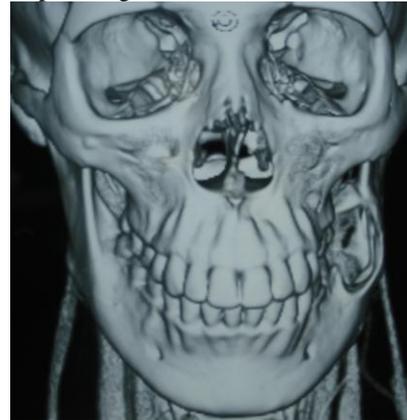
CT Showing the Lesion
